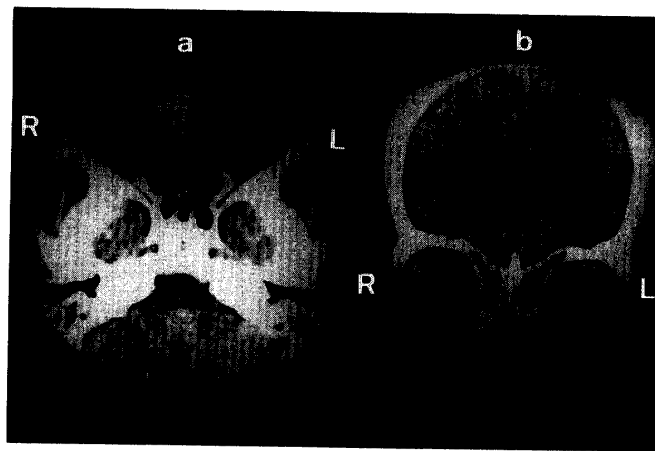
On March 4, 1988, axial (a) and coronal (b) computed tomography scans exhibit high density in the superotemporal region of the right orbit.
